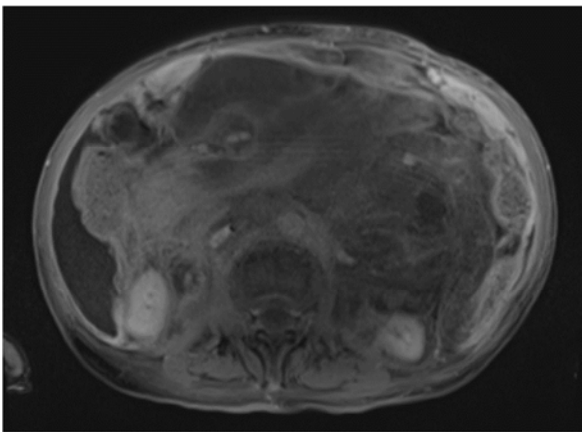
Repeat MRI (4/2021) demonstrating large volume fluid surrounding pancreas.
